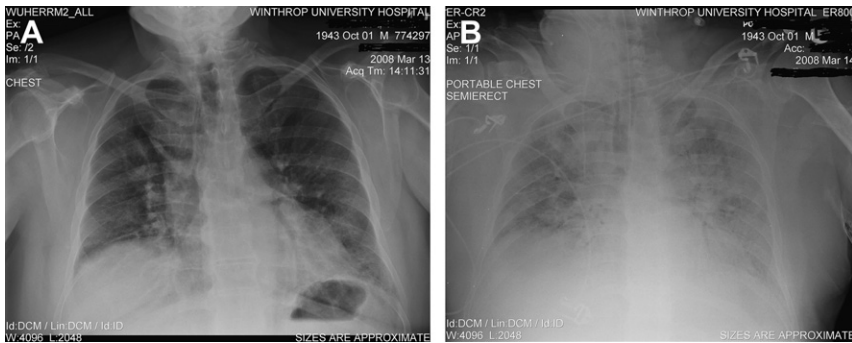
CMV CAP on chest X-rays (A, B).
